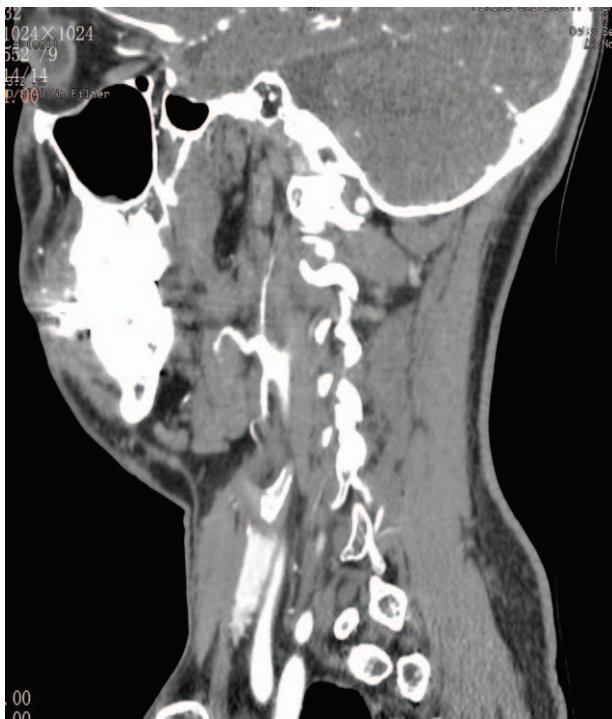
CT angiography demonstrated that the blood supply to the mass arose from small vessels of the left external maxillary artery.
